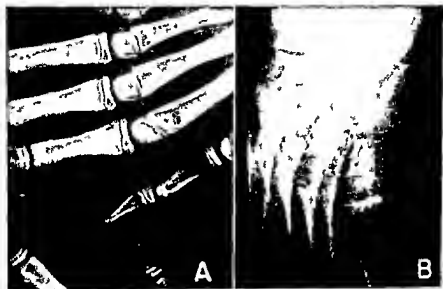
Case No 4 Acute Osteoporosis of Disuse. X-ray Films Contrasting Normal Density of Parts of Skeleton Not Immobilized [Hand (A)] with Decreased Density of Parts of Skeleton Immobilized [Foot (B)]
